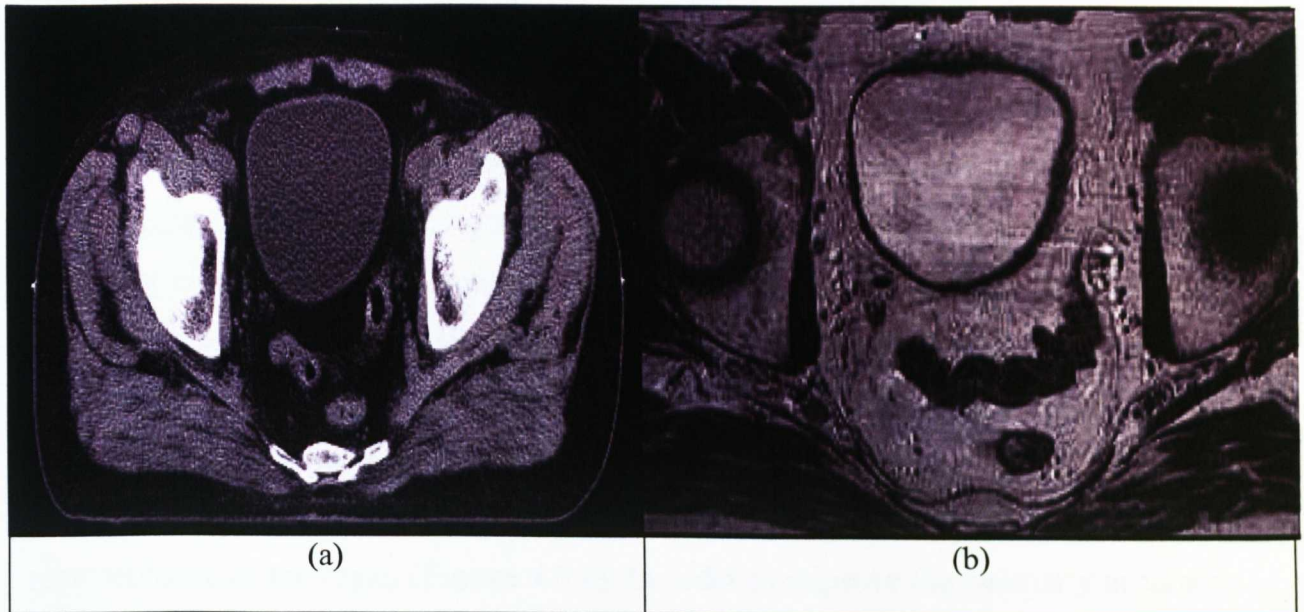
The difference in clarity between (a) CT and (b) MR images taken from transaxial orientation.
